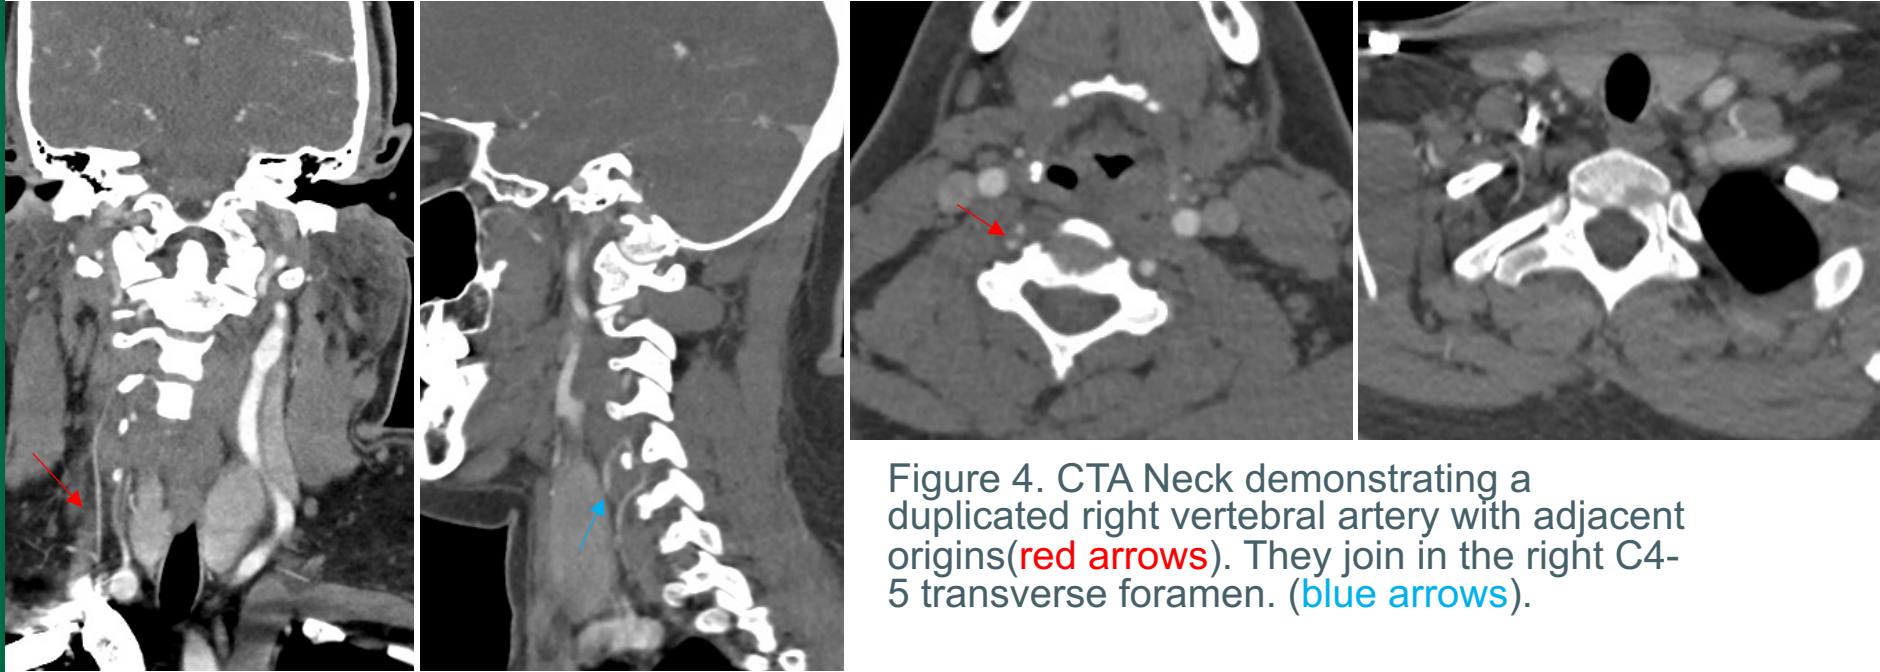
CTA Neck demonstrating a duplicated right vertebral artery with adjacent origins (red arrows). They join in the right C4-5 transverse foramen. (blue arrows).
